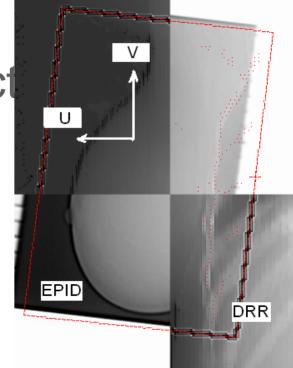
Image quality EPID & CBCT
